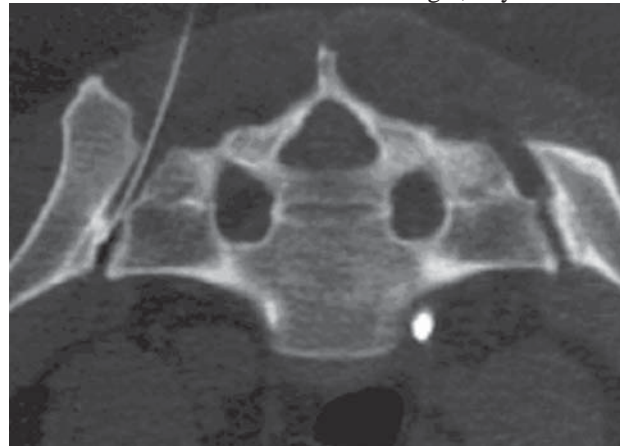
CT guided SI joint infiltration with needle within the joint space.
